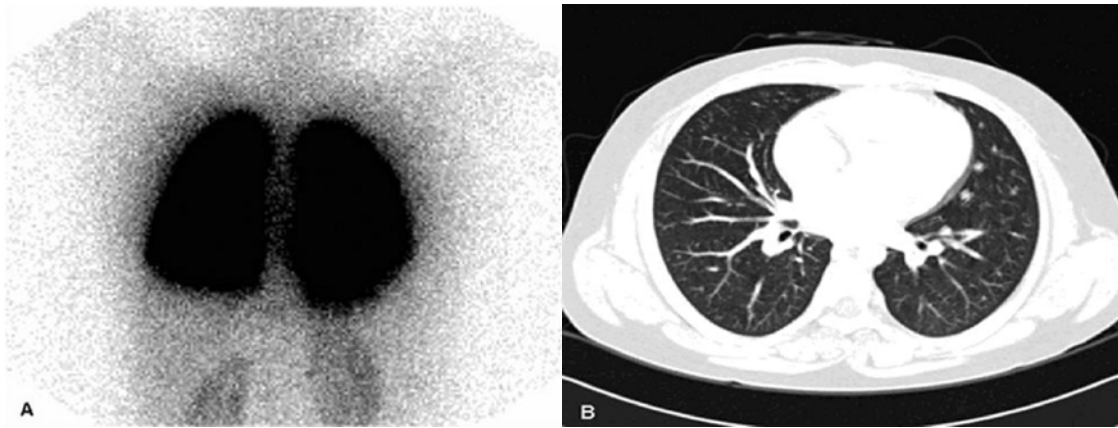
(A) Perfusion lung scan with ^{99m}Tc -MAA shows no definite perfusion defect in both lungs. Kidneys are visualized, which suggests right to left shunting of the injected ^{99m}Tc -MAA. (B) CT scan shows tortuous dilated peripheral vessels 2 cm from the pleura. The size of the arteries is increased relative to that of the adjacent bronchi.
